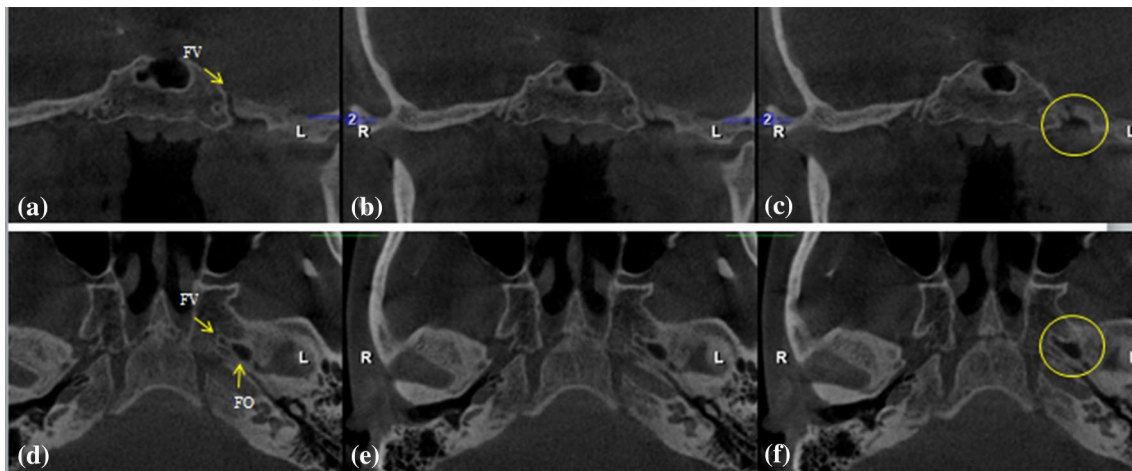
Coronal and axial CBCT slices showing the middle cranial fossa (a–f). On the left side c and f, FV confluence into FO (yellow circles). FO foramen ovale, FV foramen venosum, L left, R right
